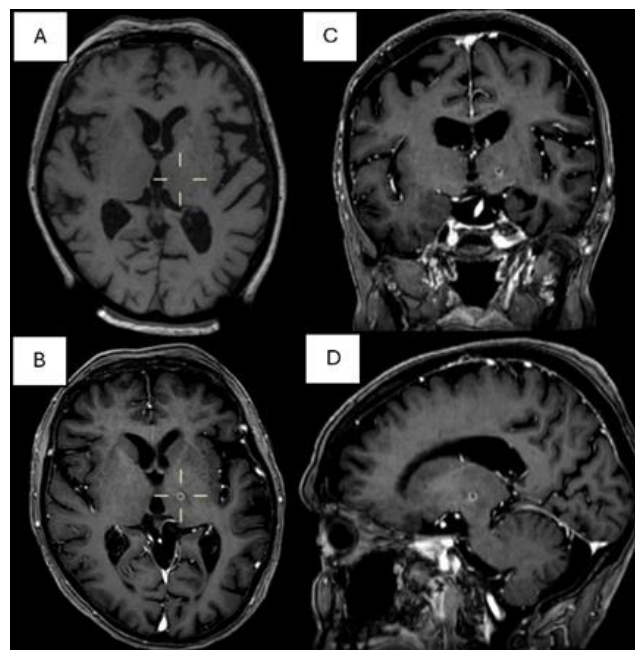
A. Axial section on 3DT1 MRI on the morning of Gamma-Knife treatment; B/C/D. Axial/coronal/sagittal section on 3DT1 MRI with gadolinium at 6 months post-treatment, left thalamic lesion with annular enhancement.
